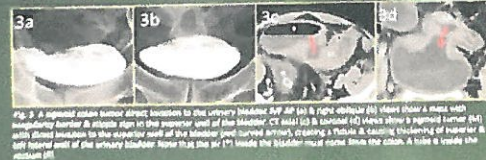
A sigmoid colon tumor direct invasion to the urinary bladder. RP AP (a) & RP sagittal (b) show spiculate sign with irregularly border. A spiculate sign in the superior wall of the bladder. CT axial (c) & sagittal (d) views show a sigmoid tumor (b) with a tract between sigmoid colon & the bases of sigmoid colon (c) & a pelvic & sacral continuity of tumor (b) and found wall of the urinary bladder (b) at the RP. Inside the bladder (b) found some tumor. A tube is inside the bladder (b).
